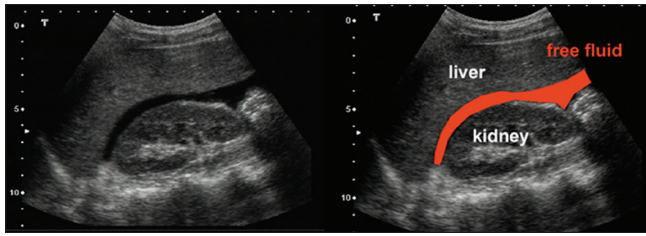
Effusion at Morrison's pouch. The computed tomography showed hepatic laceration. The bleeding was successfully stopped after an emergent transcatheter arterial chemoembolization
